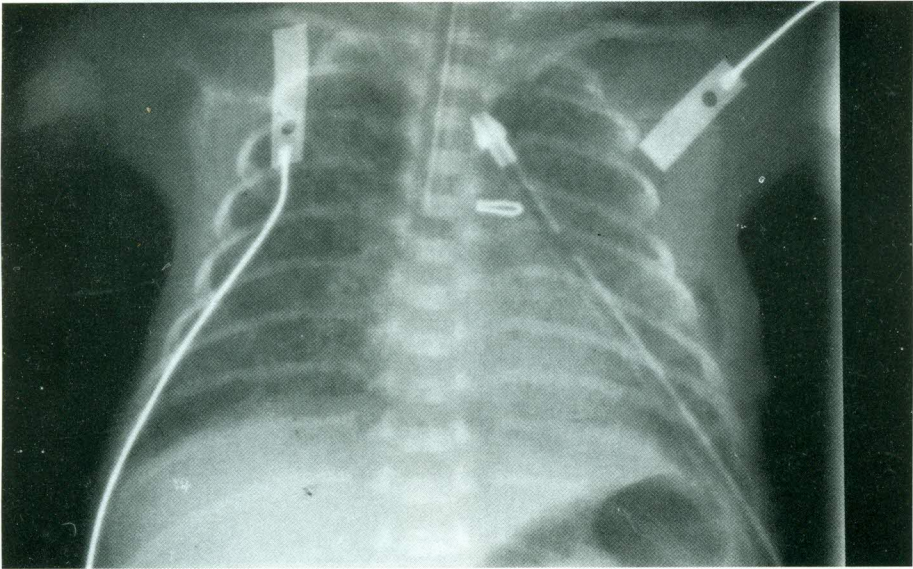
Postoperative chest X-ray showing clips at the site of the ductus, reduction in cardiac size and improved pulmonary vascularity as compared to figure(1)
